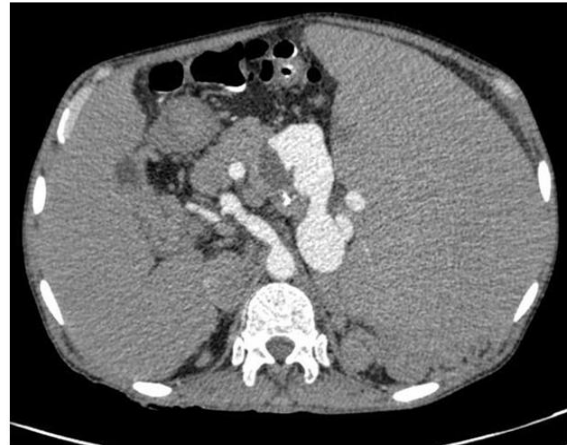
Case 1, CT scan of patient showing the SAA.
